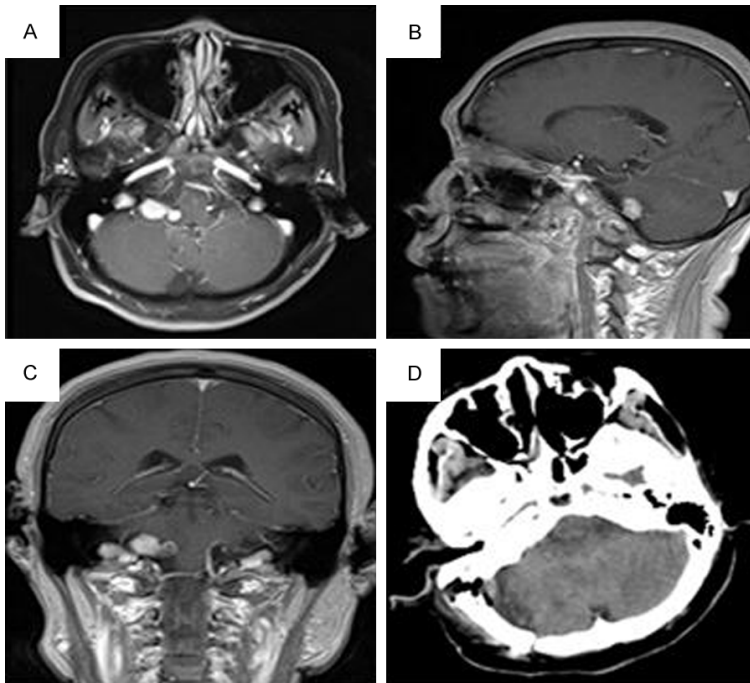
Preoperative axial (A), sagittal (B), and coronal (C) gadolinium-enhanced T1-weighted magnetic resonance imaging showing a homogeneously enhancing lesion in the cerebellopontine angle with compression of the medullary and bridge cerebellum. The largest section is approximately 22 × 12 × 10 mm. Postoperative computed tomography 1 week after surgery (D).
